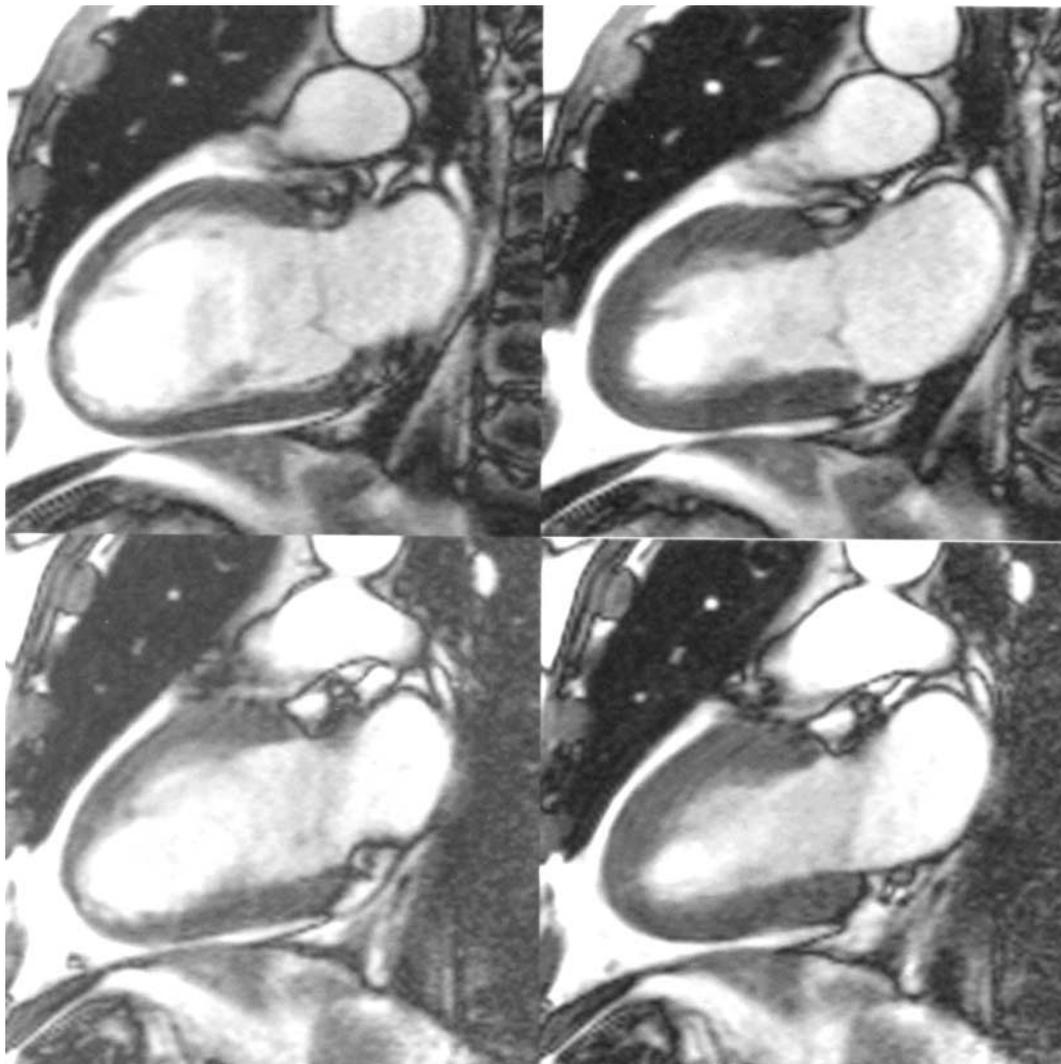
A 42-year-old man with end-stage renal disease on chronic hemodialysis. Vertical, long-axis cine MR images in end-diastole (left) and end-systole (right). Above: before dialysis; below: immediately after dialysis treatment. Mild concentric LV myocardial hypertrophy is present (LVMM, 157 g; LVMI, 103 g). The difference in EDV (left column) between the scans before (EDV_{pre} , 181 mL) and after dialysis (EDV_{post} , 120 mL) is obvious. ESV also decreases through the dialysis from 79 mL to 64 mL.
